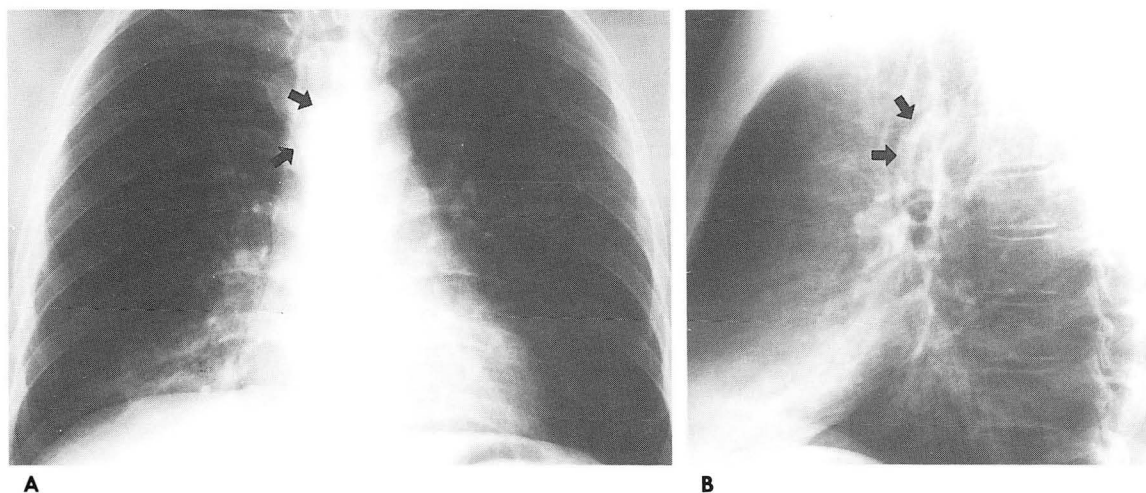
A. PA chest radiograph shows ill defined increased density (arrows) in lower trachea.
